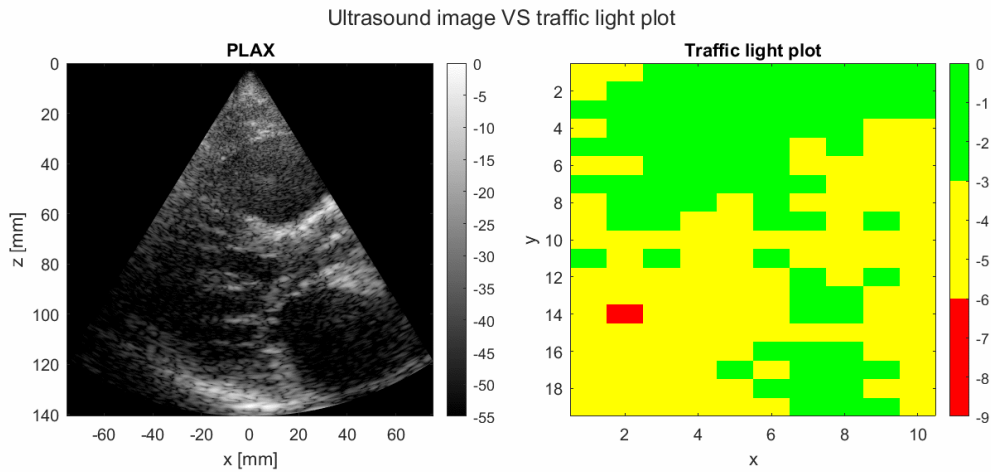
An ultrasound image and the corresponding traffic light plot of the recording with the maximum amount of yellow energy reduction level, which was 52.79%.
